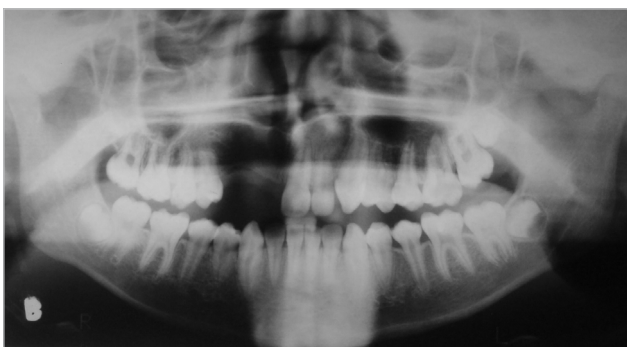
Panoramic radiographic after 2 years.
